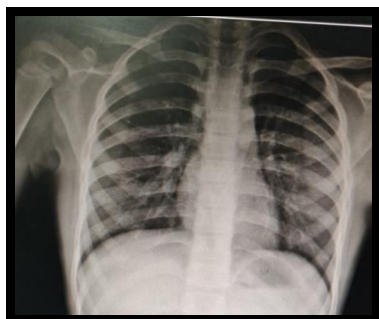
Chest Xray appears to be normal.
